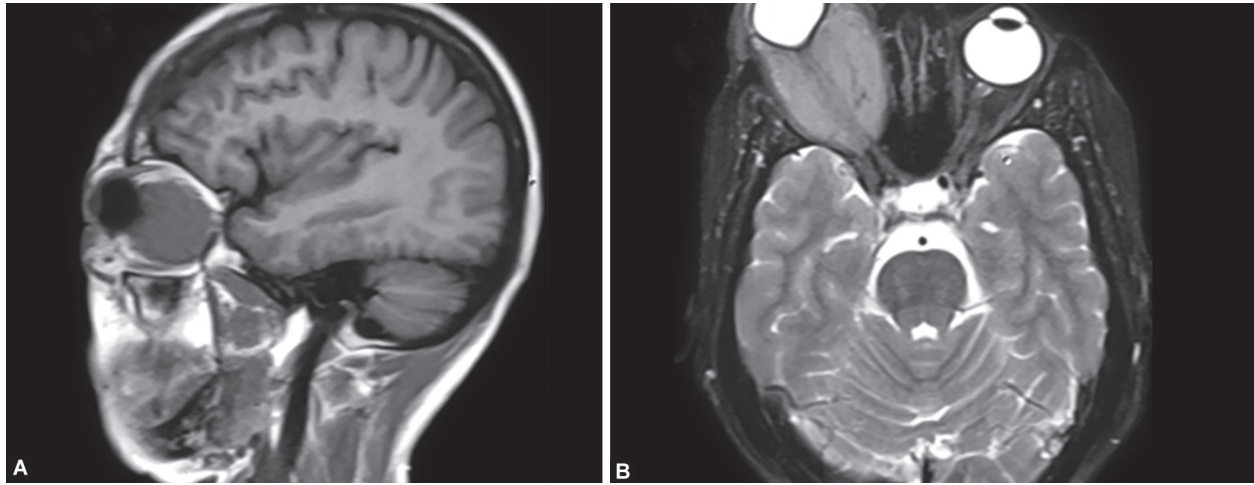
MRI T1 and T2 weighted images show an isointense intraocular space-occupying lesion in the right eye
